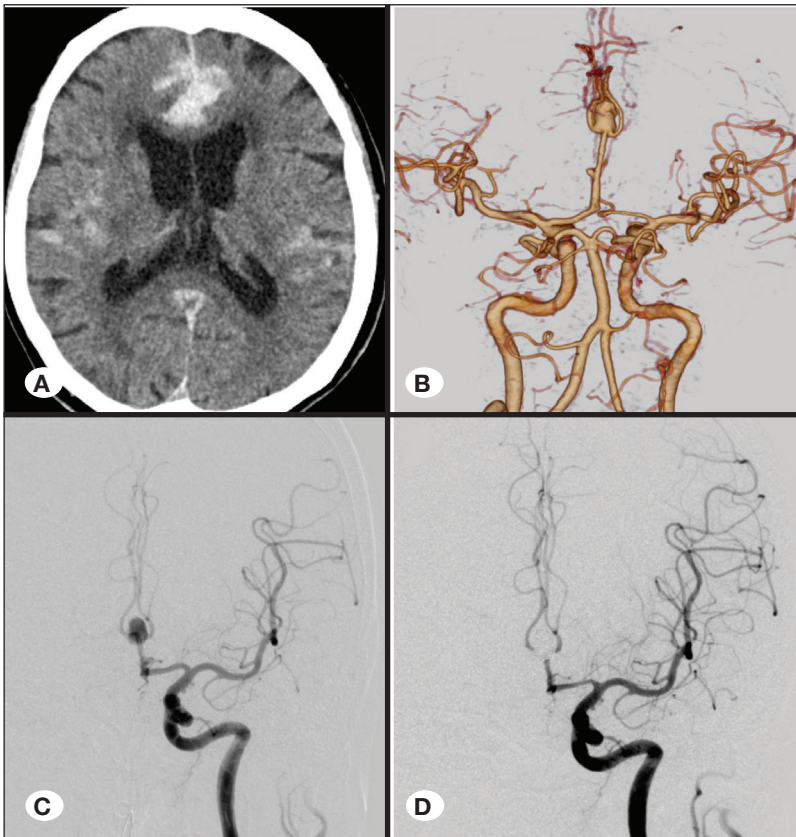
A) Initial CT of the brain showed subarachnoid hemorrhage and hematoma in the interhemispheric fissure. B, C) CT angiography and left ICA angiogram (Anteroposterior view) depicted an azygos ACA and a distal ACA aneurysm. D) Left ICA angiogram after coil embolization showed complete occlusion of the aneurysm.
